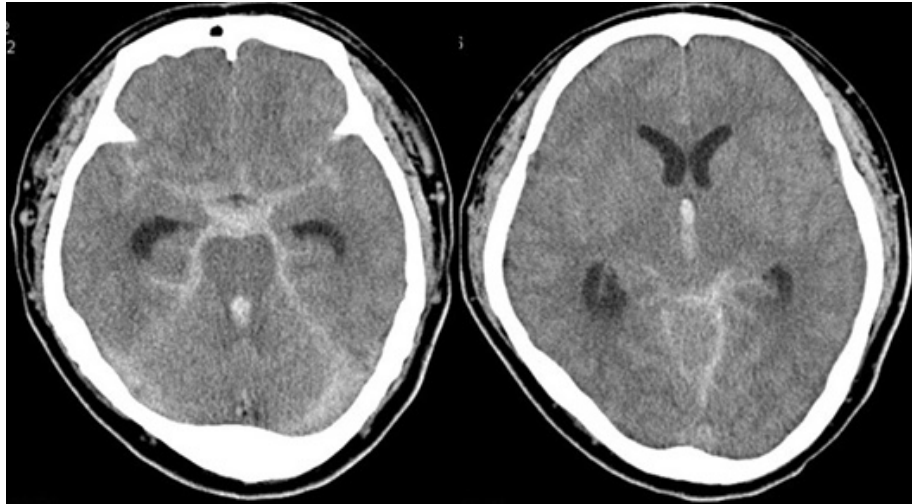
Brain CT showing subarachnoid hemorrhage at the point of second re-bleeding from the ruptured vertebral artery dissecting aneurysm.
